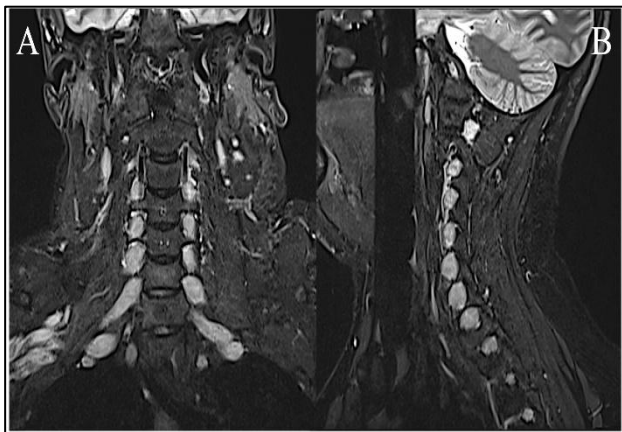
(A) Coronal T2 fat-saturated sequence MRI demonstrating bilateral hypertrophied nerve root involving the nerve root from C1 till T1; (B) sagittal T2 fat-saturated sequence MRI demonstrating the hypertrophied exiting nerve root from C1 till T1.
